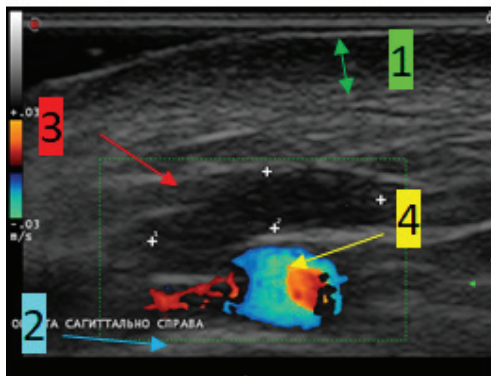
Sonogram of the periorbital region in Color Doppler mode in the projection of the nasolacrimal groove, sagittal plane at the level of the bone edge of the orbit (arrow 1 – dermis, arrow 2 – bone). Hypoechoic avascular formation of an oblong shape with clear and even contours is visualized into the soft tissues of the examined area (arrow 3 – hypoechoic formation). It was adjacent to the vessel (arrow 4 - vein), the blood flow spectrum showed that it was vein, with no signs of tissue edema. Echo signs of adjacent to the vein cosmetic filler in the projection of the nasolacrimal groove
